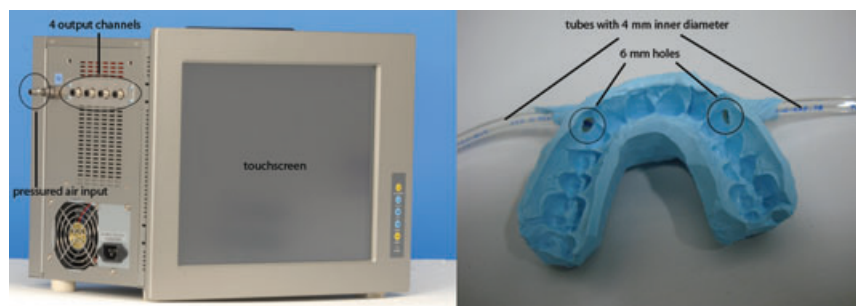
Stimulation material. Left: MRI compatible multi-injector gas jet delivery system with touch screen. Right: Individual dental polysiloxane impression.
